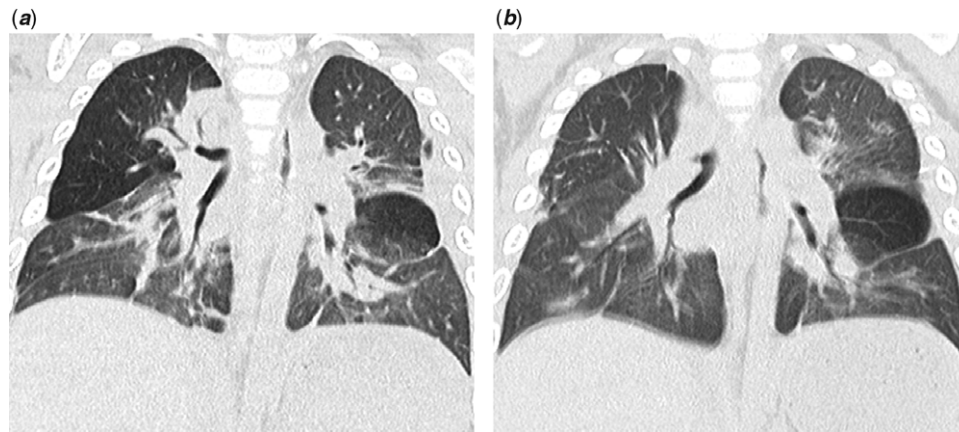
(a) Chest computed tomography shows hyperinflation of the right upper lobe and left lower lobe. (b) Postoperative chest computed tomography shows a residual lesion in the left lower lobe.
